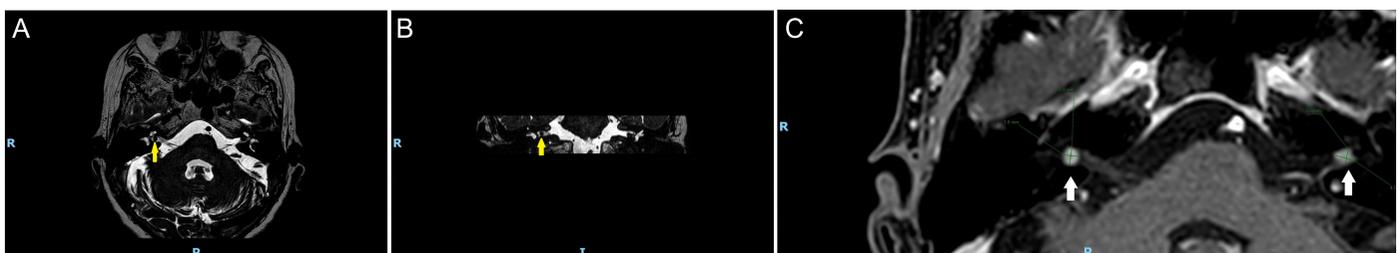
T1- and T2-weighted MRI evidencing (yellow arrow in T2 images) the growth of the right intracanalicular VS (A) axial T2; (B) coronal T2; (C) axial T1. MRI, magnetic resonance imaging; VS, vestibular schwannomas.
